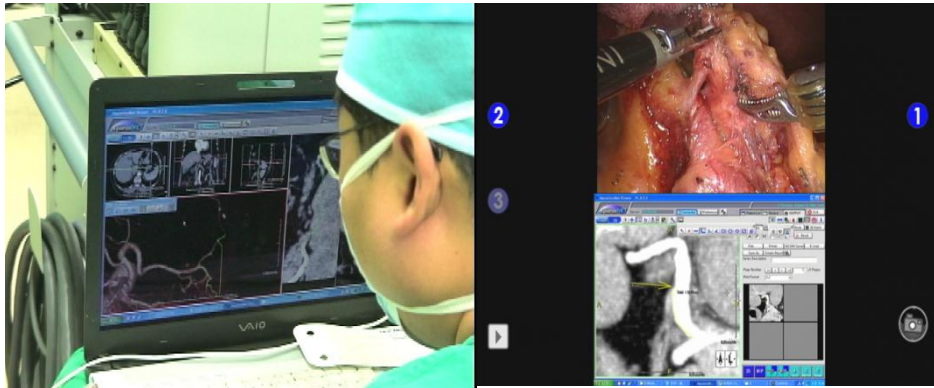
Image-guided robot assisted gastrectomy using Tile-pro®. The radiologist reconstructs 3D-CT images during operation (Right). The real operation field on the top and reconstructed CT image on the bottom (Left)
